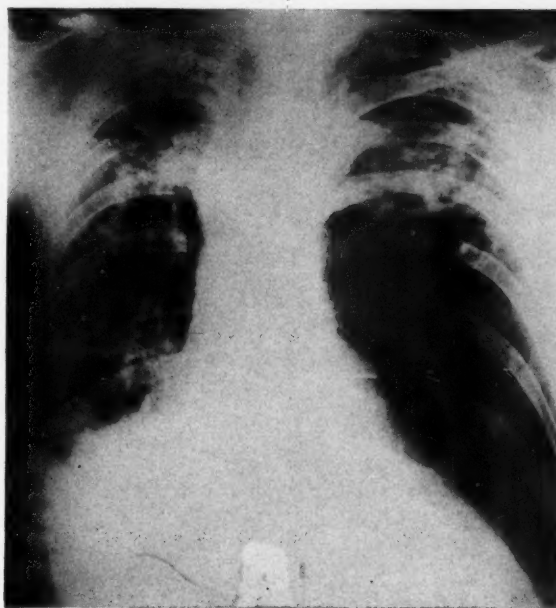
Case VI. Roentgenogram of chest; full inspiration.
